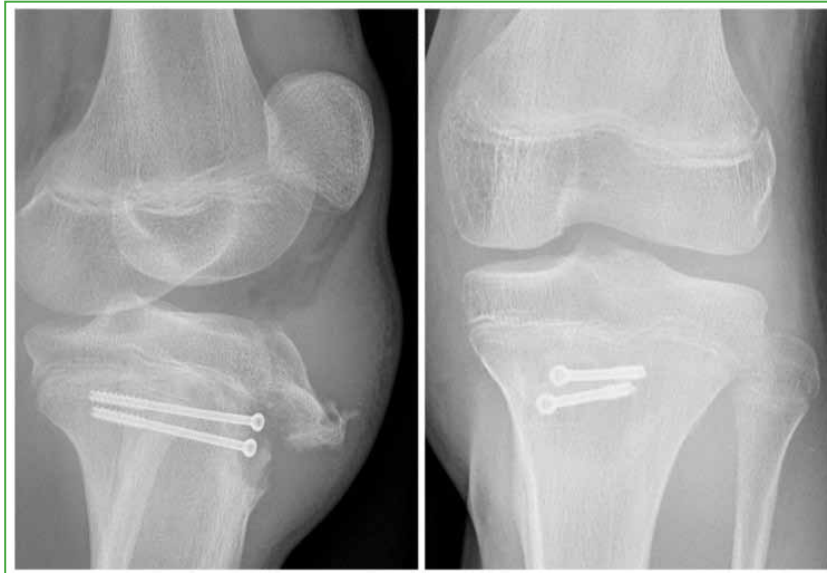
Anteroposterior and lateral radiographs of the knee. The refracture is observed.
